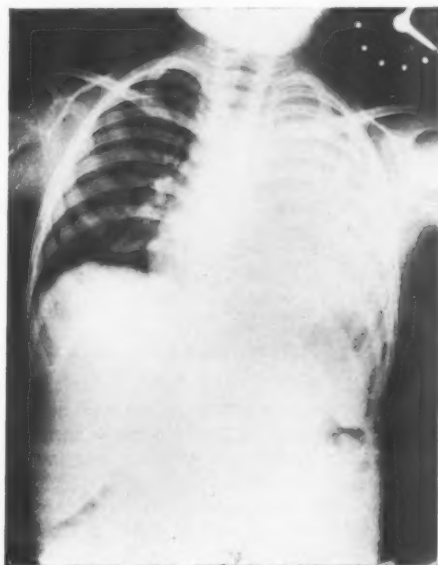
Radiograph of child aged 5 years on admission. A total left empyema is present with displacement of the mediastinum to the right.
